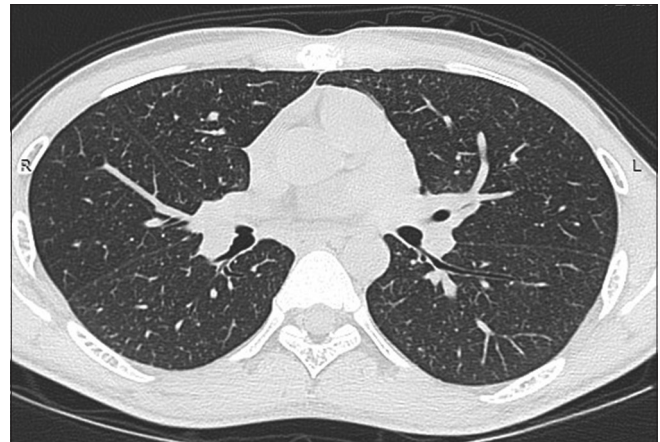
High resolution computed tomography thorax image showing bilateral randomly distributed nodules
